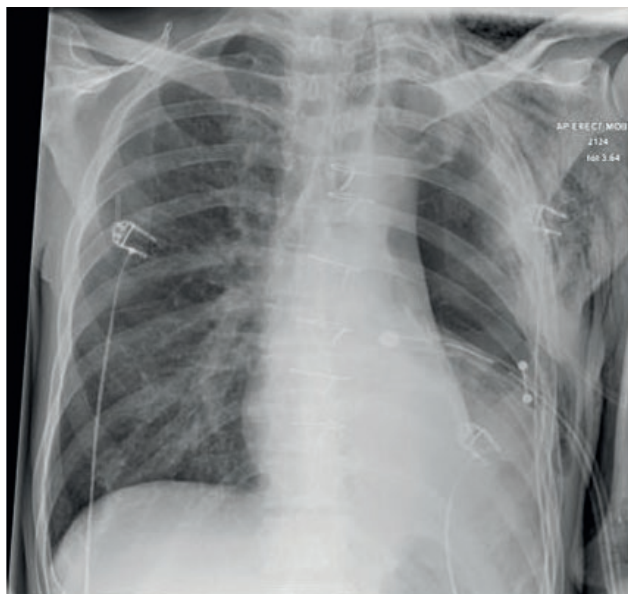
Chest radiograph following drain insertion with resultant improvement in mediastinal shift back towards the pneumonectomy space
